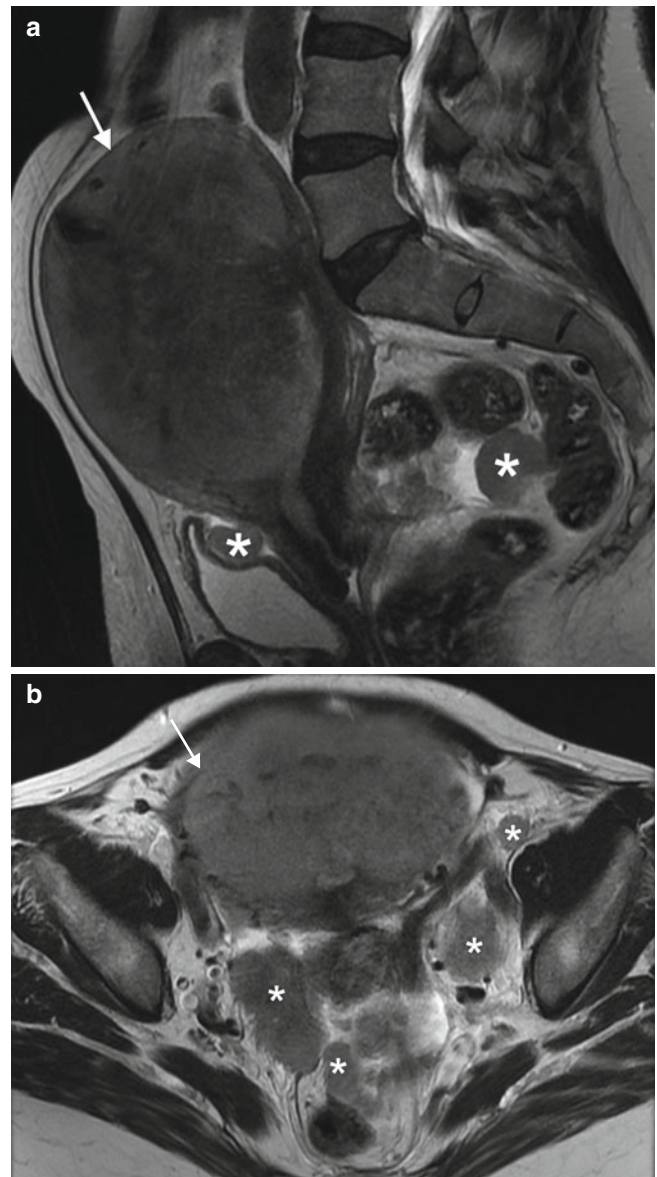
FIGO stage III endometrial cancer in a 52-year-old woman complaining of increasing abdominal girth and irregular perimenopausal vaginal bleeding. Sagittal (a), axial (b), and coronal (c) T2-weighted MR images and a sagittal, fat-suppressed T1-weighted image following intravenous gadolinium (d) demonstrate a large, heterogeneously enhancing endometrial mass extending to the serosa (arrows). Bilateral metastatic involvement of pelvic nodes is also present (asterisks). Pathology was reported as undifferentiated endometrial adenocarcinoma
